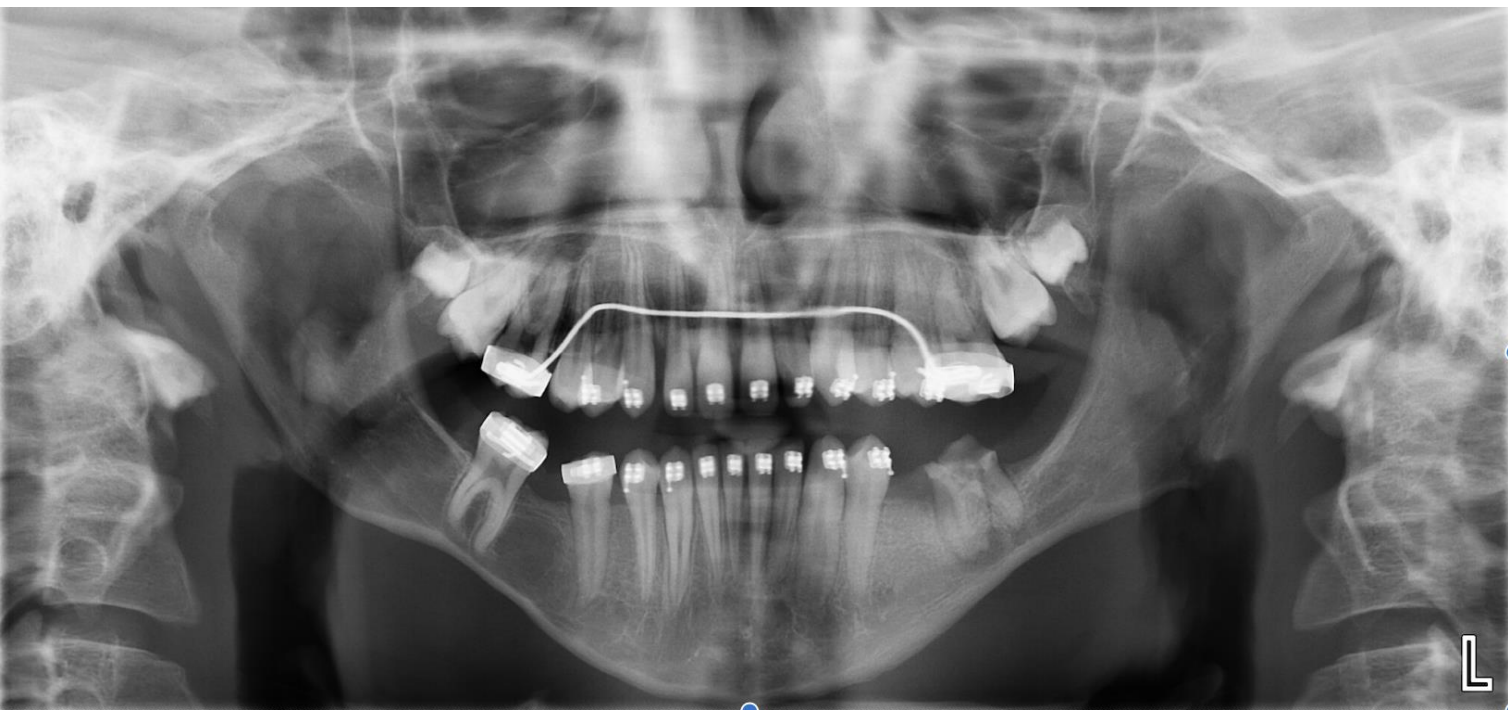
Panoramic Radiograph
